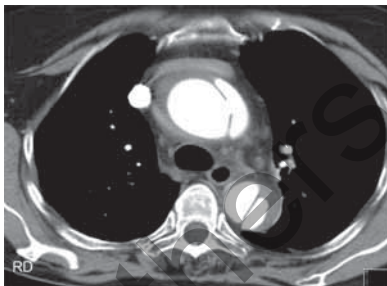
Computed tomography angiographic cross-section showing dissection flap in both the ascending as well as the descending thoracic aorta with proximal intimal tear in the ascending aorta
